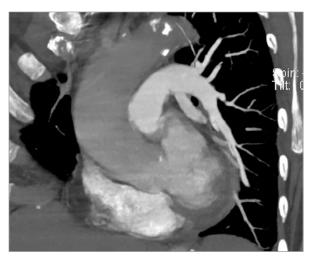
Computed tomographic angiogram shows a dilated ascending aorta.
